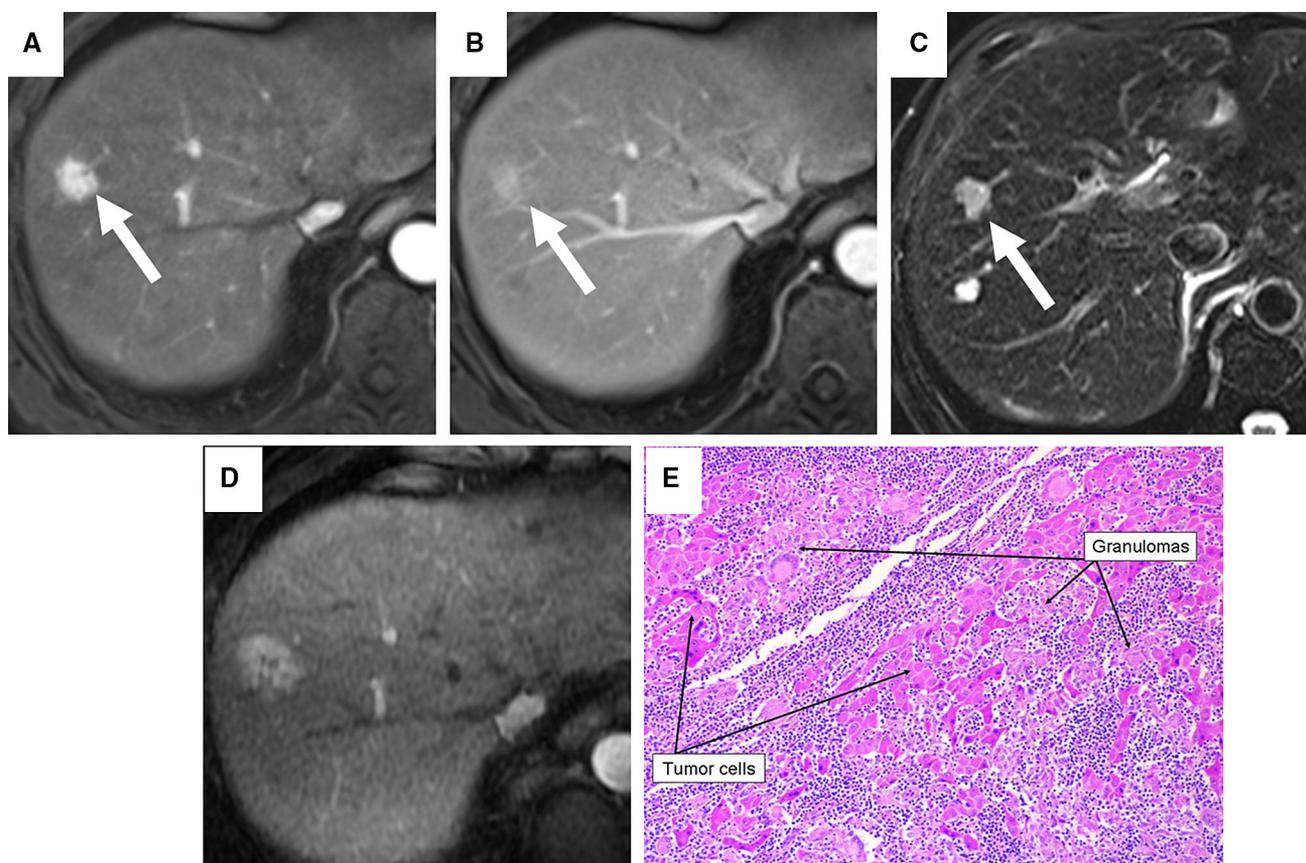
Contrast-enhanced MRI of the liver was performed for this patient with Hepatitis B and Child's A liver cirrhosis. MRI revealed a nodule (arrowed) that showed arterial enhancement (A) and retention of contrast on the portal venous phase (B). The lesion also showed high T2 signal (C) and was initially
